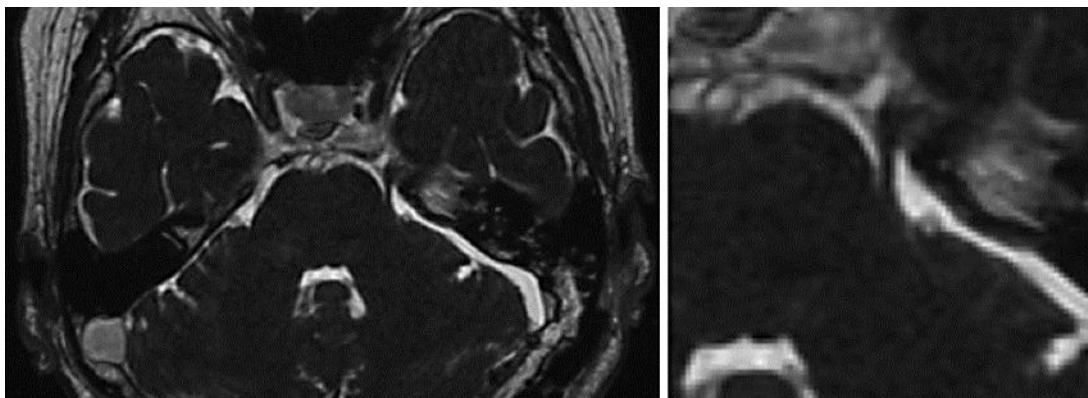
Postoperative 3D FIESTA MR images showing the gross total removal of the tumor and the decompressed and straightened trigeminal nerve root.
